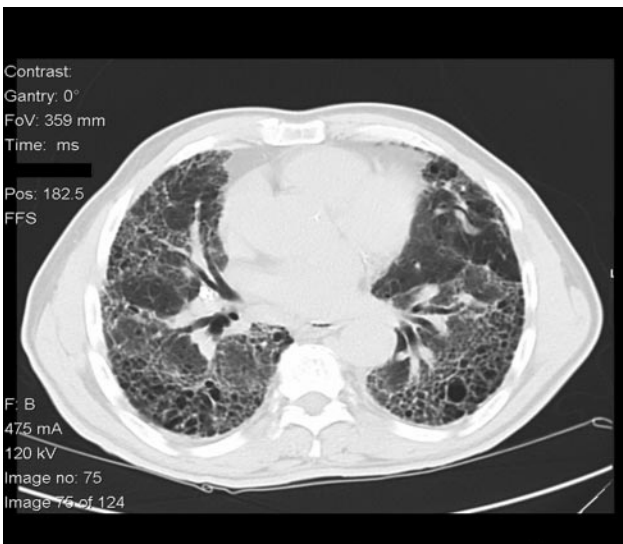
High-resolution computed tomogram shows lower lobe subpleural honeycombing, fibrosis, and traction bronchiectasis.
